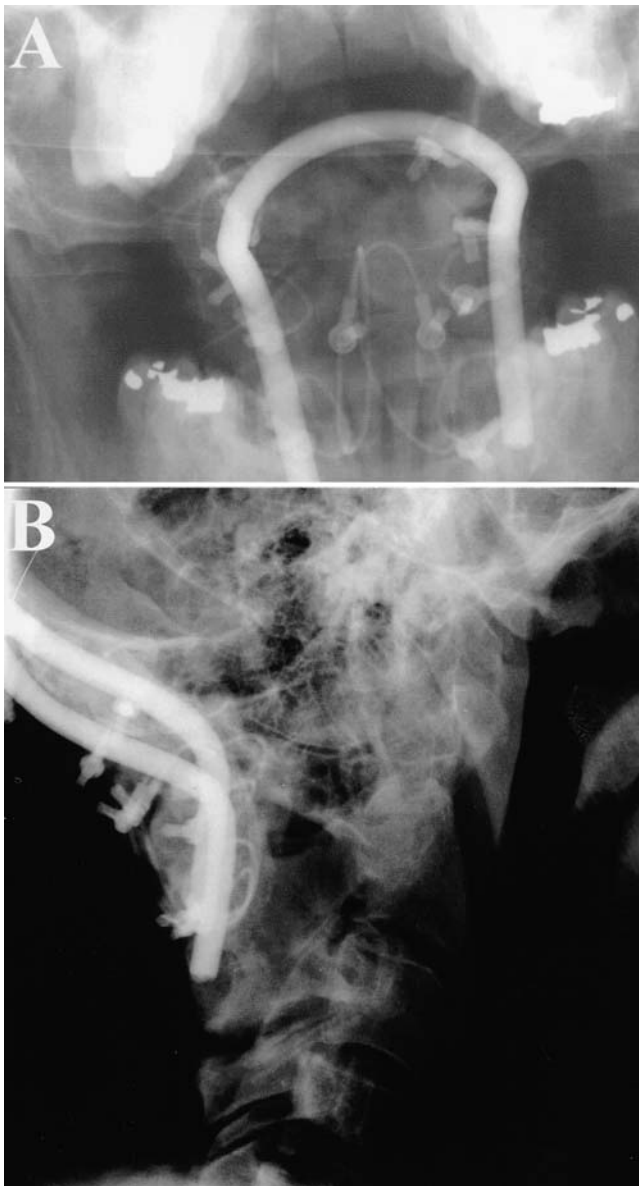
X-ray films revealing an open mouth view (A) and a lateral view (B) of the cervical spine following internal stabilization. The type of injury incurred by this patient leads to bone dissociation of the head and spine. Reconstruction required fusion of the occiput to C-2 with titanium rods, wire, and bone graft.
